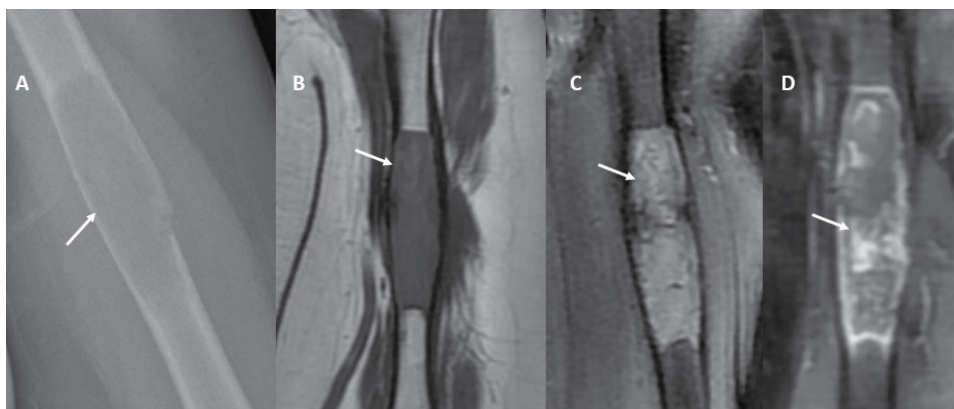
Fibrous dysplasia: Left humerus radiograph (A) demonstrates an expansile diaphyseal lesion (white arrow) with a ground-glass matrix. The lesion (white arrows) demonstrates hypointense T1 signal (B), heterogeneous but predominantly increased T2 signal (C), and heterogeneous postcontrast enhancement (D).
